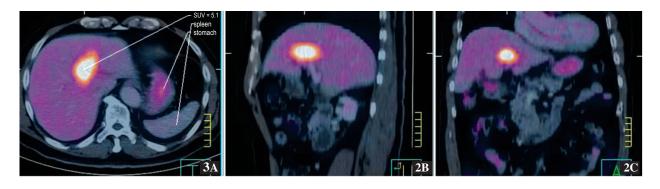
The PET/CT scan showed liver mass at segment 3 of liver with increasing metabolic activity SUV of 5.1.
